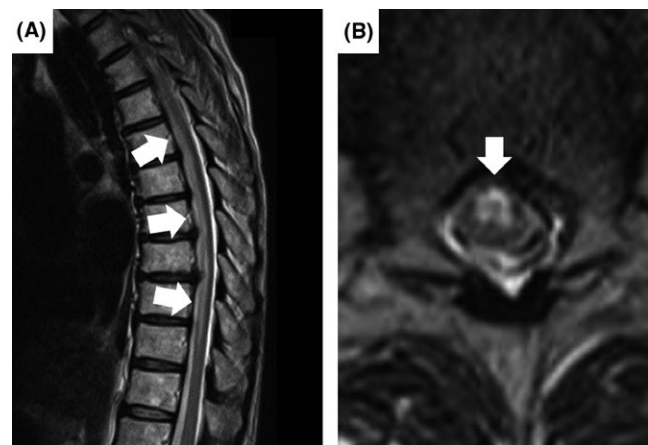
(A) Magnetic resonance imaging revealing abnormally high signal intensity in the thoracic cord, extending from T5 to T10 on a sagittal T2-weighted image. (B) An axial T2-weighted image showing “owl’s eye sign” involving central-anterior cord
